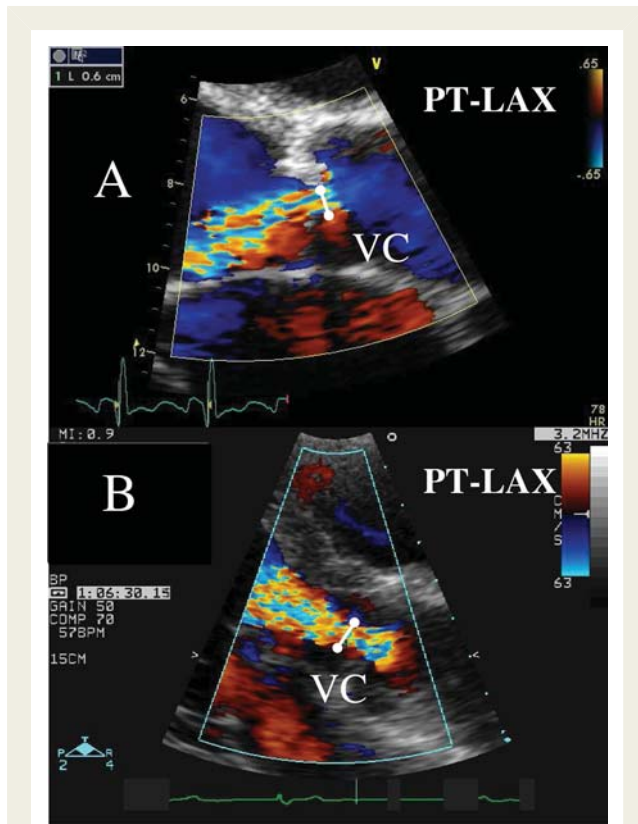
Two other examples of the measurement of the vena contracta (VC) width in two patients with moderate aortic regurgitation. PT-LAX, parasternal long-axis view.
